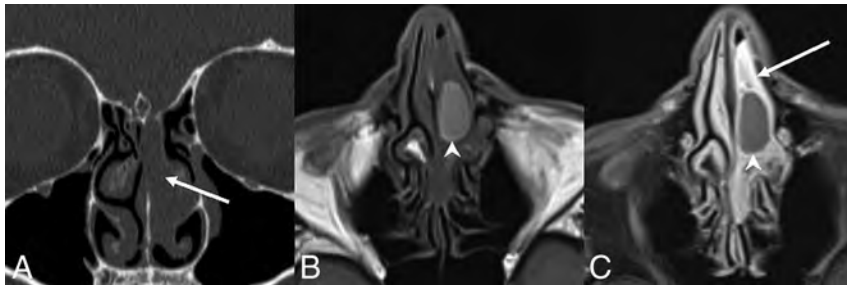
SH. A, Coronal noncontrast CT shows expansile soft tissue in the left olfactory recess extending inferiorly into the superior nasal cavity (*white arrows*) without erosive or destructive bony changes, similar to an REAH. Axial T1 precontrast (B) and axial T1 postcontrast, fat-saturated (C) images demonstrate predominantly homogeneous enhancement. The relatively hyperintense, nonenhancing central component on T1WI suggests proteinaceous content (*white arrowheads*), possibly reflecting glandular secretions. Areas of relative central hyperintense signal on precontrast T1WI are not described in other published examples.
